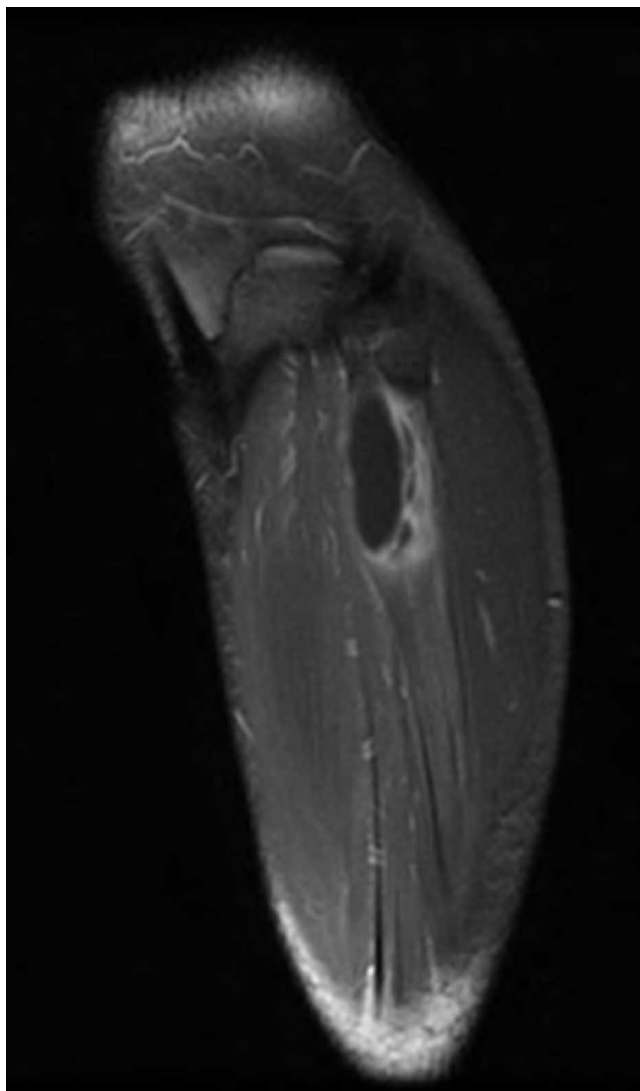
Ruptured peroneal ganglion cyst. Post-gadolinium T1 fat-saturated sagittal MRI shows enhancement of the cyst walls but not of the cyst contents or the surrounding tissues. The fluid tracking distally along the fascial planes does not enhance.
